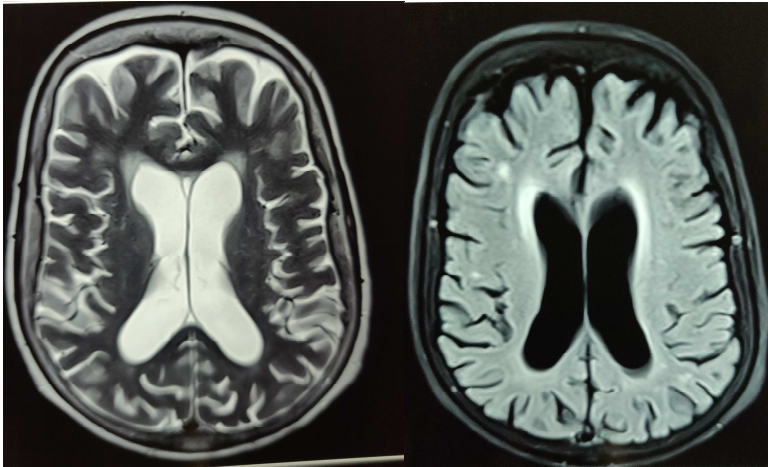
Magnetic resonance imaging (MRI) showing cerebral atrophic changes.
